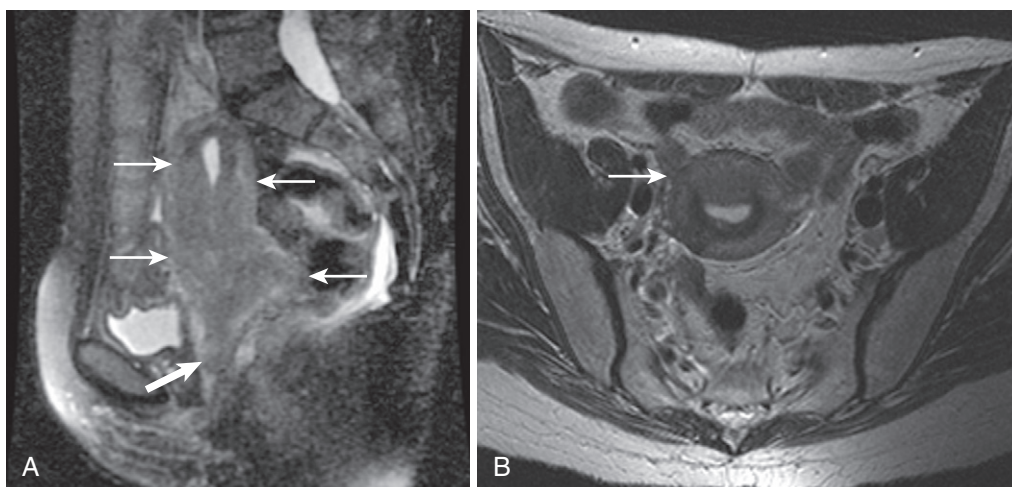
Cervical carcinoma extending cephalad to endometrium/uterus. A, Sagittal midline T2-weighted image depicts loss of the normal cervical and lower uterine mural stratification pattern as a consequence of an infiltrative mass (thin arrows) obscuring both the cervical fibrous stroma and the inner myometrium. The mass also extends into the upper vagina (thick arrow in A). B, Axial T2-weighted image through the level of the uterine body shows the infiltrative mass (arrow) obliterating the junctional zone and invading the myometrium.
